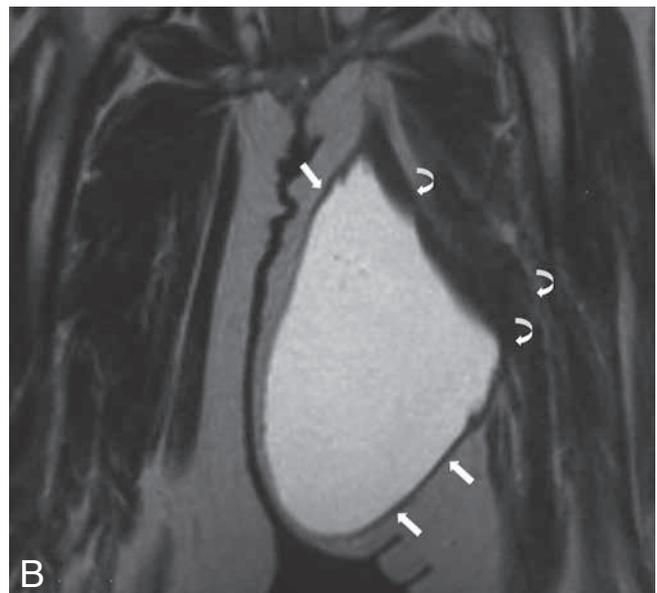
The MRI of the left thigh on the coronal plane showing a giant cystic mass hypointense on T1 (A) and hyperintense on T2 (B) weighted images with a hypointense rim on both sequences (arrows). Note that the gracilis and adductor muscles are displaced (curved arrows).
